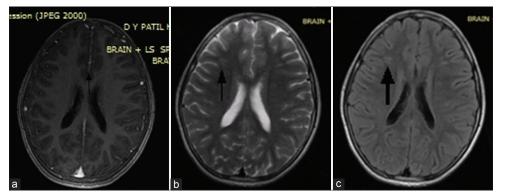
(a-c) Hyperintense areas in frontal lobe on fluid-attenuated inversion recovery and T2-weighted and no enhancement on contrast study
